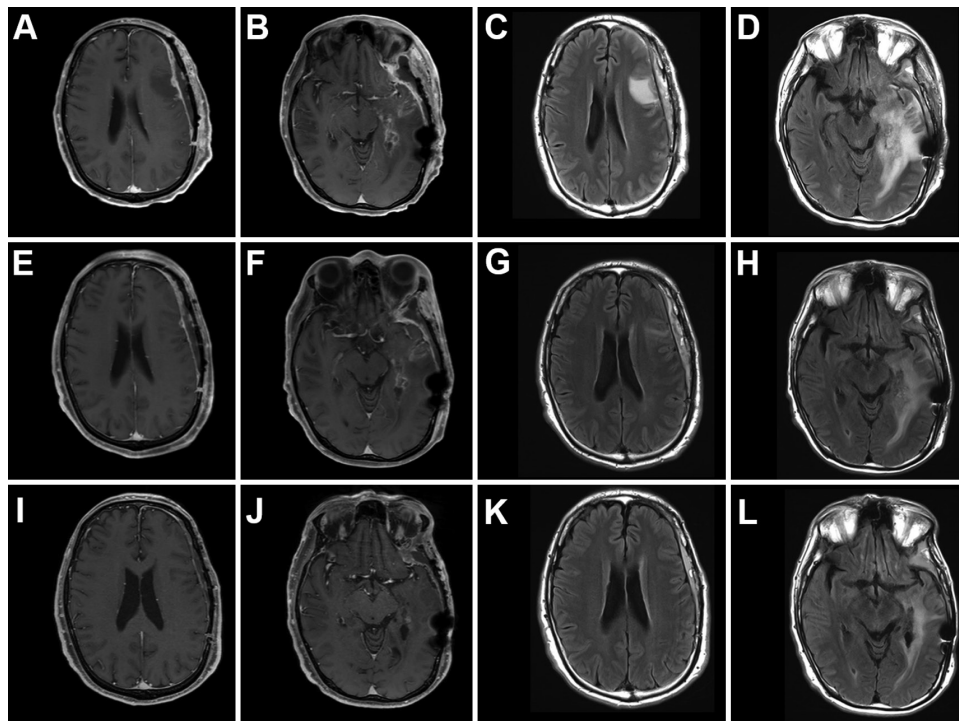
Imaging changes following the initiation of dabrafenib and trametinib. A–D: Axial MR images at the time of tumor dissemination. MRI performed on POD 56 revealed contrast-enhancing lesions with dural enhancement in the left frontal and temporal lobes. FLAIR imaging revealed hyperintense regions surrounding the lesions, indicating perilesional edema. Dabrafenib and trametinib therapy was initiated on POD 74. E–H: Axial MR images following the initiation of dabrafenib and trametinib therapy. By day 15 following treatment initiation, the dural contrast enhancement in the left frontal lobe had regressed, and the hyperintense regions on FLAIR imaging in the left frontal and temporal lobes has diminished, suggesting a positive therapeutic response. I–L: Axial MR images obtained 28 weeks after the initiation of dabrafenib and trametinib, demonstrating the disappearance of most abnormal contrast-enhancing regions.
